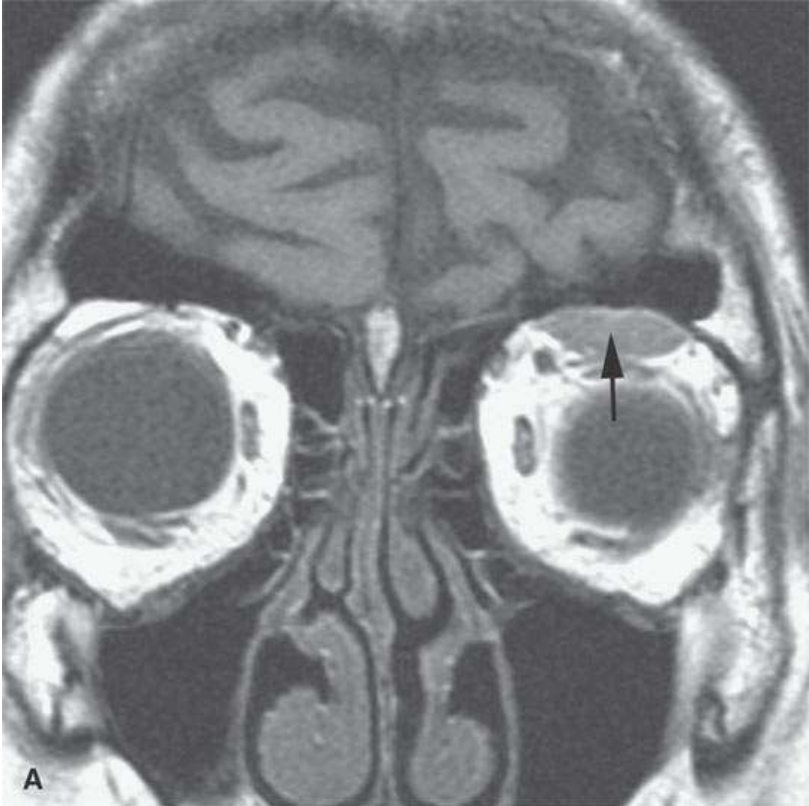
Magnetic resonance imaging of a patient with a subacute orbital subperiosteal hematoma induced by straining. A: T1-weighted non–contrast-enhanced image shows the collection of blood (*arrow*) to be isointense to brain. B: T2-weighted image shows that the collection (*arrow*) is still relatively isointense to brain. C: There is no change on the T1-weighted contrast-enhanced image (*arrow*). The combination of findings is consistent with an organized, subacute clot not yet having undergone significant clot lysis or conversion of hemoglobin to methemoglobin.
